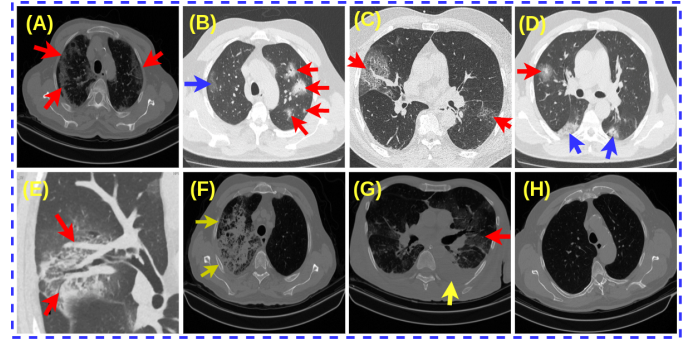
Clinical image findings: The imaging findings of COVID\_19 and CAP in chest CT scans. Images (A)-(E) show the COVID-19 patient's chest CT scan slices, (F) and (G) show the CAP patient's chest CT scan slices. (A) Peripheral distribution of GGO in both lungs (red arrows). (B) Patchy areas of consolidations in the left lung (red arrow) and GGOs in the right lung (blue arrow). (C) Crazy paving pattern: GGOs with superimposed septal thickening (red arrows). (D) Halo sign: consolidations surrounded by GGOs (red arrow), consolidations at the lower lobes of lungs (blue arrow). (E) Subsegmental vessel enlargement near the lesion (red arrow). (F) An extensive area of consolidations with GGO in the right lung – severe disease. (G) Pleural effusion (yellow arrow) and GGOs (red arrows) in the left lung. (H) Normal chest CT scan slice.
